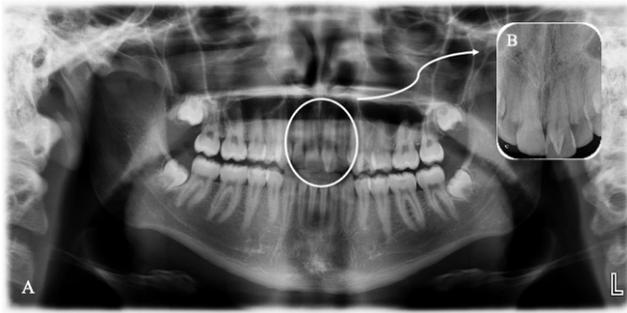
A) Panoramic radiography of the patient with no other pathology. B) Periapical radiograph of taloned tooth in which pulp tissue was not fully visualized.
